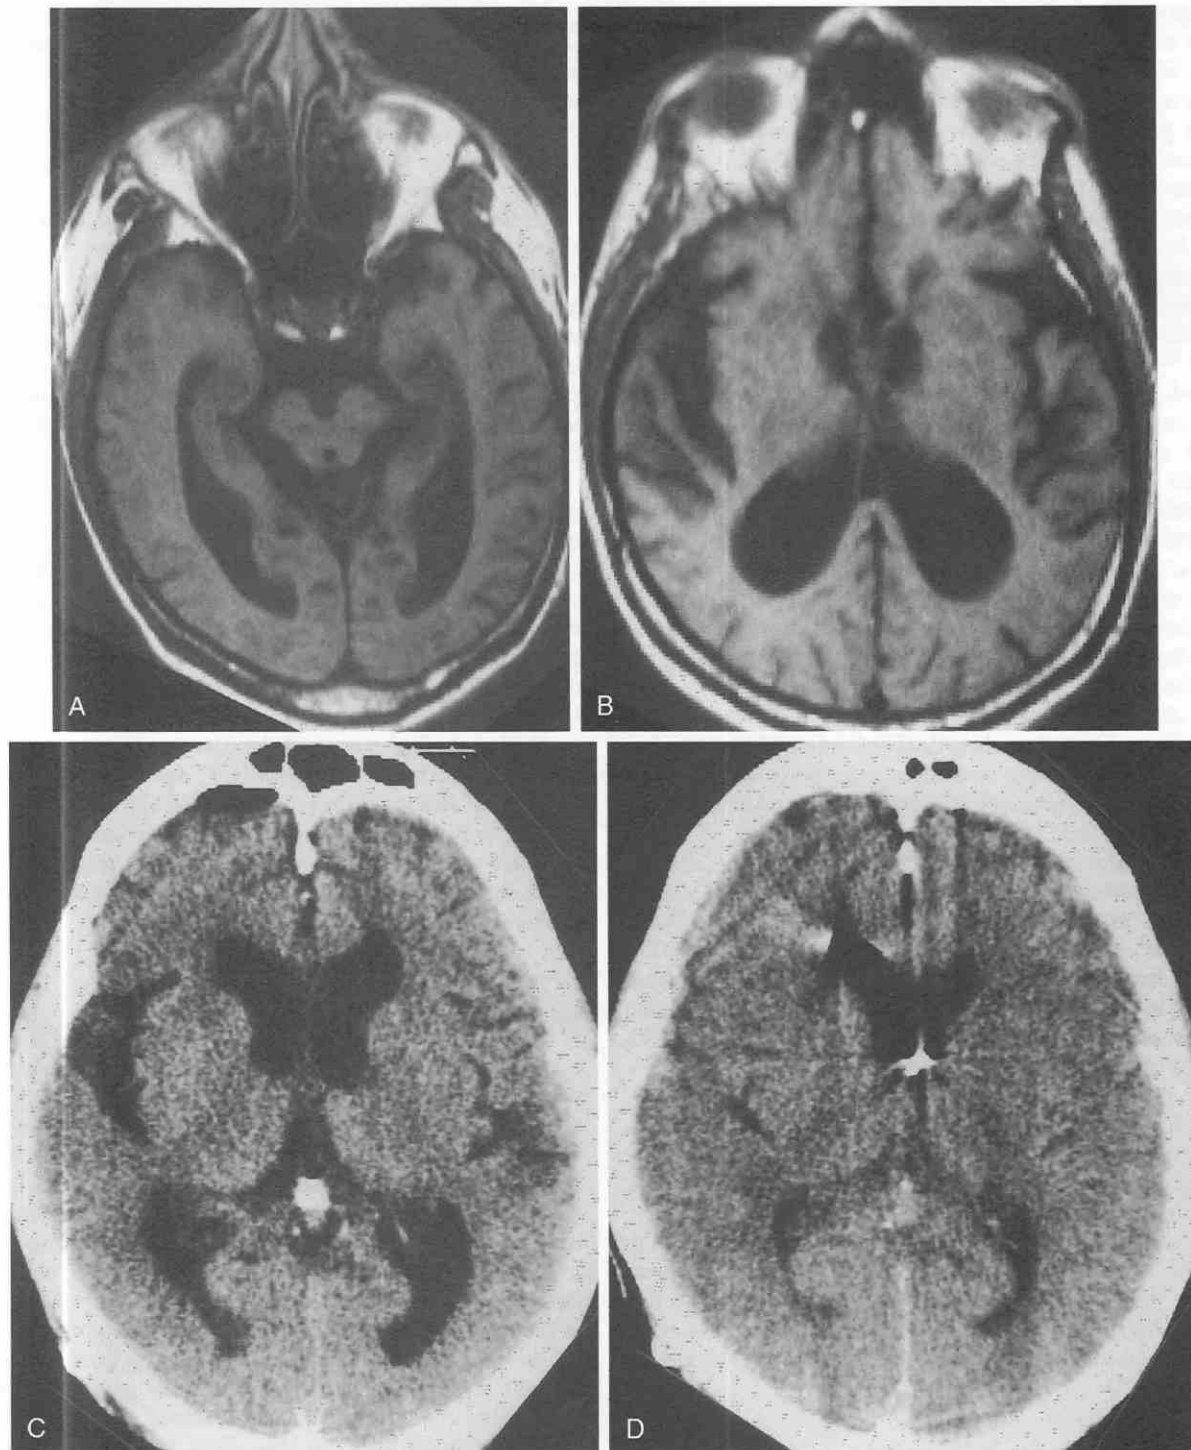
Normal-pressure hydrocephalus in a 68-year-old man with paradoxical collapse of the sylvian fissures. *A* and *B*, Axial T1-weighted images demonstrate enlarged lateral ventricles, including the temporal horns as well as moderately distended sylvian fissures. Several months after successful shunting, the patient returned with recurrent symptoms. *C*, A CT scan demonstrated evidence of shunt failure with distention of the lateral ventricles. Sylvian fissure dilatation was also present. *D*, Following shunt revision, a CT scan demonstrated a decrease in the size of the lateral ventricles as well as a decrease in the size of the sylvian fissures. (From Holodny AI, George AE, de Leon MJ, et al: Focal dilatation and paradoxical collapse of cortical fissures and sulci in patients with normal-pressure hydrocephalus. *J Neurosurg* 89:742-747, 1998.)
